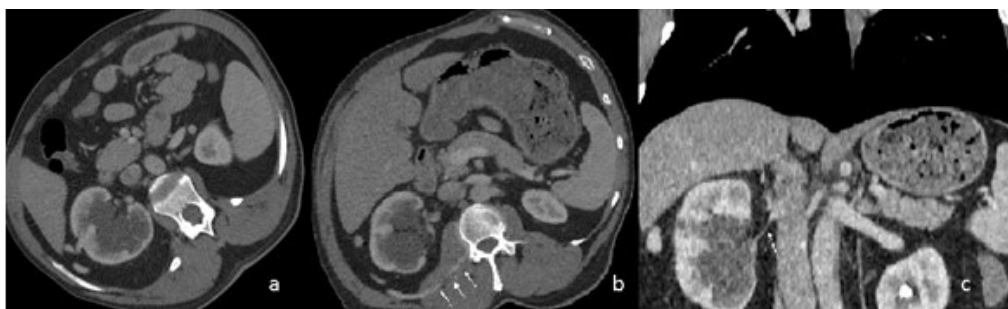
Axial contrast-enhanced CT images (a,b) show an abnormal renal vein, originated at the midportion of right kidney on the anti-hilar side, coursing in the pararenal fat space, and draining to lumbar venous plexus (arrows). (c). Coronal reformatted CT image shows band-like right renal vein (arrow) with a normal vein on the left.
